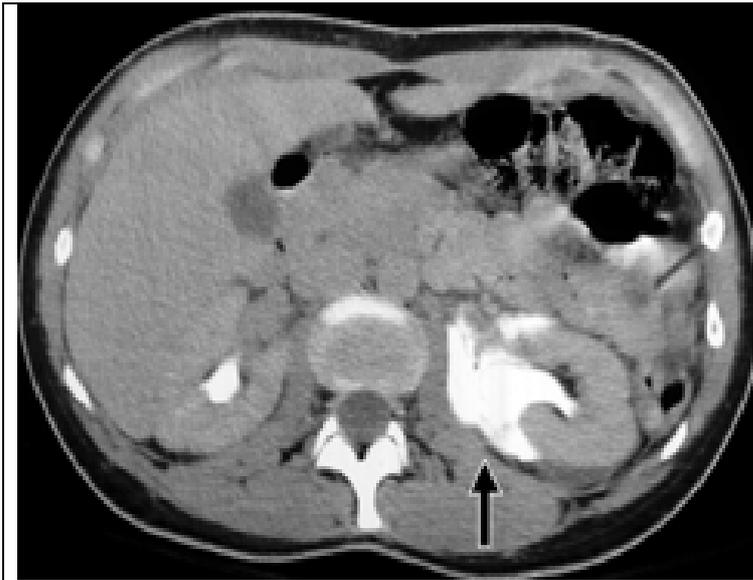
Axial contrast-enhanced CT section through the kidneys showing extravasation of contrast (arrow) from a left kidney, due to traumatic fornical rupture. Renal trauma.
